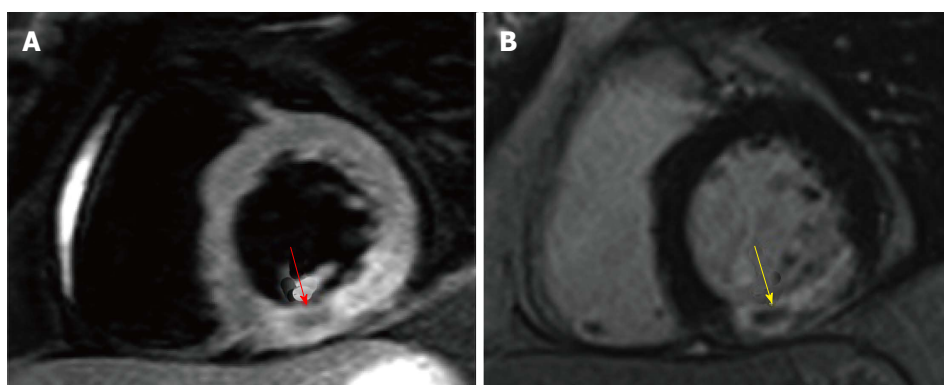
Intramyocardial haemorrhage on cardiovascular magnetic resonance. A: T2-weighted spin-echo image with hypointensity corresponding with IMH within the hyperintense oedematous region in the inferior wall (red arrow); B: Corresponding LGE image showing co-localisation of IMH and L-MVO (yellow arrow). IMH: Intramyocardial haemorrhage; LGE: Late gadolinium enhancement; MVO: Microvascular obstruction.
